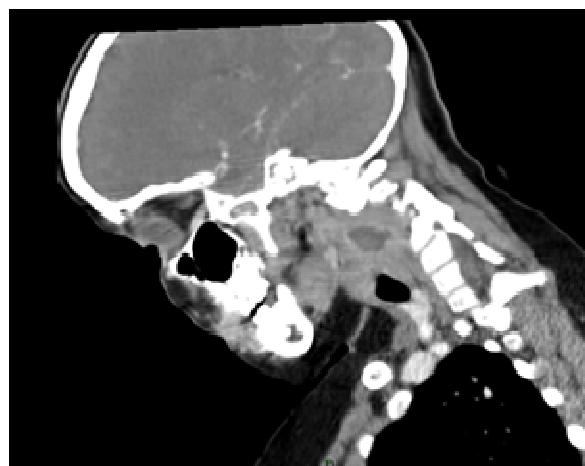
CT scan: the abscess in r the retropharyngeal space with compression of larynx and vertebral muscles.
